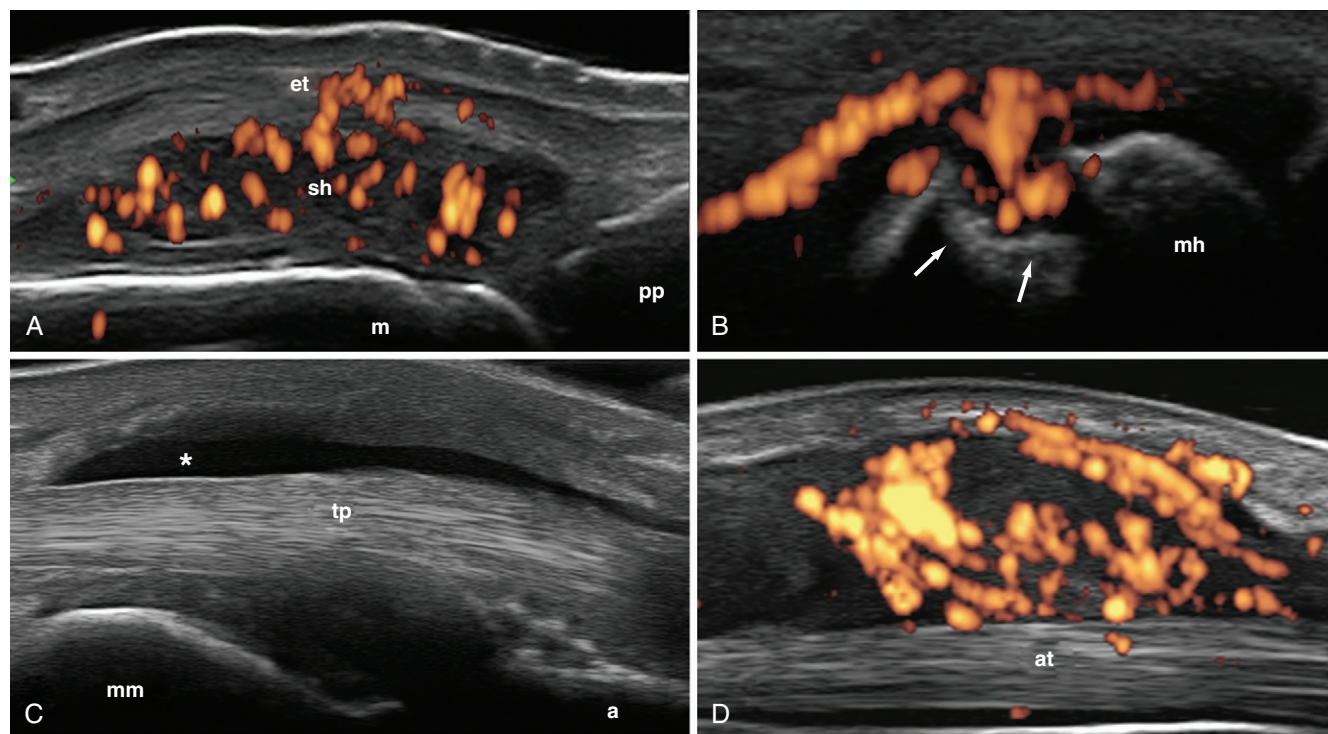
Rheumatoid arthritis (ultrasonography). A, Metacarpophalangeal joint (dorsal longitudinal scan): joint cavity widening, synovial hypertrophy (sh), and intense power Doppler signal. B, Fifth metatarsophalangeal joint (lateral longitudinal scan): large bone erosion (arrows) associated with power Doppler signal inside the erosion. C, Tibialis posterior tendon (tp): tendon sheath widening with homogeneous anechoic aspect of the content (fluid collection) (asterisk). D, First compartment of the finger extensor tendons (longitudinal scan): chronic tenosynovitis characterized by synovial hypertrophy and intense power Doppler signal. a, astragalus; at, abductor pollicis longus tendon; et, common extensor tendon of the finger; m, metacarpal bone; mh, metatarsal head; mm, medial malleolus; pp, proximal phalanx.
